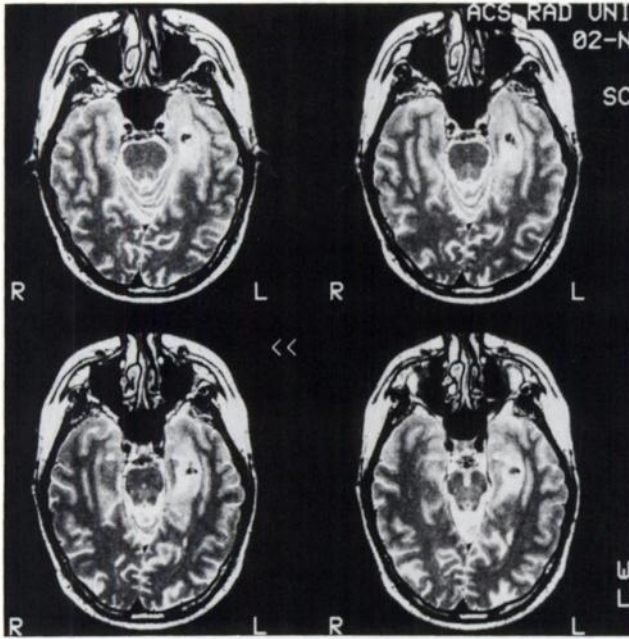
MRI scan (T2-weighted sequences, four transaxial slices, parallel to the long-axis of the temporal lobes, 2.0/0.2 mm thickness). A signal increase is detected in the mesial part of the left temporal lobe. A circumscribed signal decrease is visible in the ventral part of the lesion.
